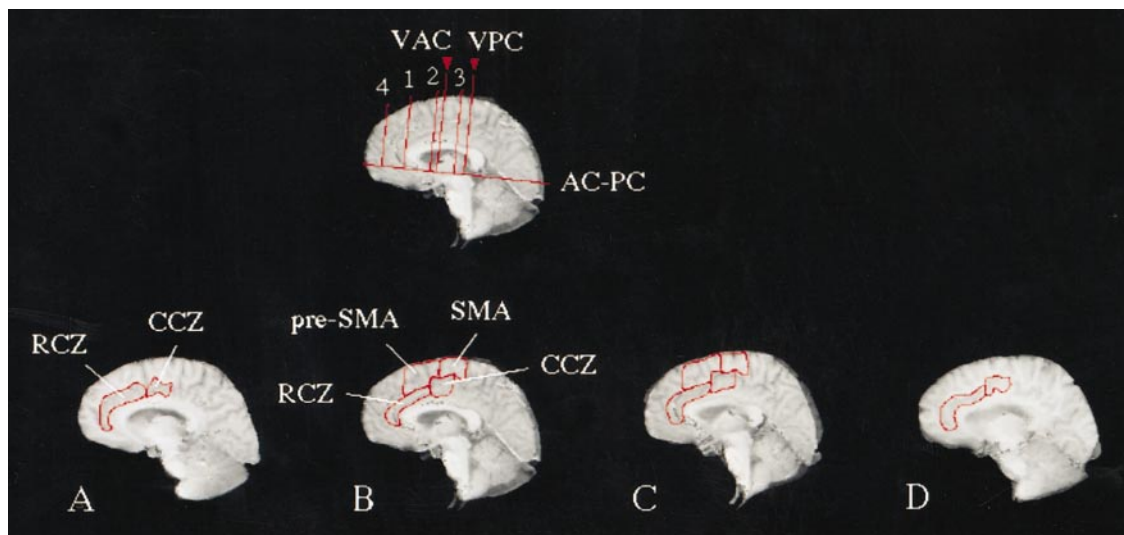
High-resolution magnetic resonance images from 1 subject: sagittal slices 6-mm thick. *A* and *B*: left hemisphere; *C* and *D*: right hemisphere. Interhemispheric fissure is located between *B* and *C*. The landmarks used to trace the regions of interest (ROIs) are shown on slice *B* (top), according to the scheme of Picard and Strick (1996). Pre-SMA, rostral portion of the supplementary motor area; SMA, caudal portion of the supplementary motor area, corresponding to the SMA proper; RCZ, rostral cingulate zone; CCZ, caudal cingulate zone; AC-PC, horizontal line passing through the anterior and posterior commissures; VAC, vertical line perpendicular to AC-PC, passing through the anterior commissure; VPC, vertical line perpendicular to AC-PC, passing through the posterior commissure; 1, vertical line delimiting the pre-SMA anterior boundary (from VAC, percentage of total anteroposterior brain dimension: 17.1%); 2, vertical line delimiting the CCZ anterior boundary (3.7%); 3, vertical line delimiting the CCZ posterior boundary (9.4%); 4, vertical line delimiting the RCZ anterior boundary (28.6%). Pre-SMA and SMA are traced on the more medial slice in each hemisphere (*B* for the left hemisphere, *D* for the right hemisphere), and RCZ and CCZ are traced on the 2 more medial slices in each hemisphere (*A* and *B* for the left hemisphere, *C* and *D* for the right hemisphere).
